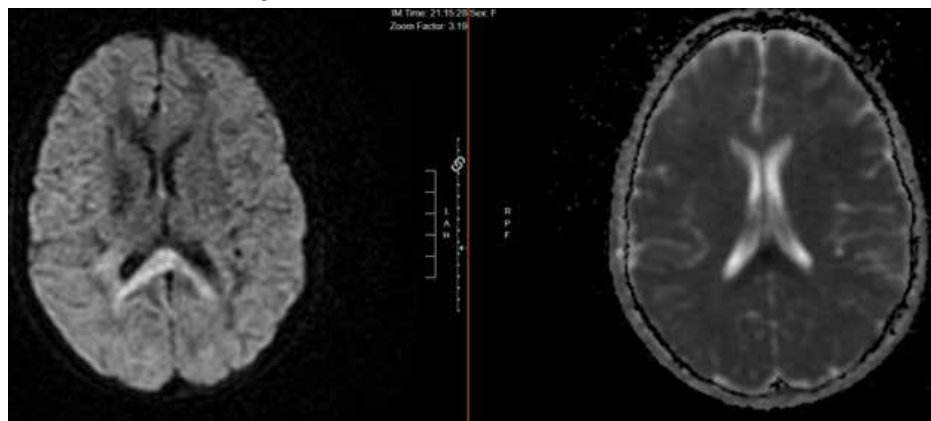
MR Brain w/w/o contrast read as areas of acute infarction in splenium of corpus callosum and deep parietal white matter bilaterally. Areas of increased signal on FLAIR weighted images are suspicious for encephalitis/meningitis given history.
